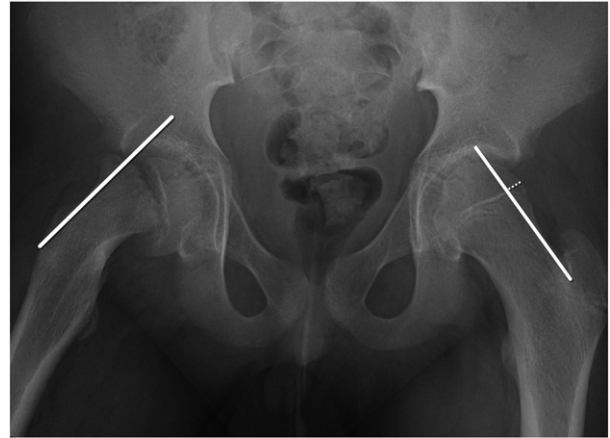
Anterior-posterior hip radiographs of a patient with right-sided SCFE. Klein lines are drawn in solid white. The line on the left hip intersects the femoral head (epiphysis), where the right line does not intersect the femoral head due to its slippage. The dotted line on the left hip shows the measurement of the femoral head that is lateral to the Klein's line as discussed in the text. On the right, there is no mass of the femoral head lateral to Klein's line as there is a significant slip. In mild slips, a difference of 2 mm between the distances the femoral head extends laterally to the Klein's line may be an early indicator.
